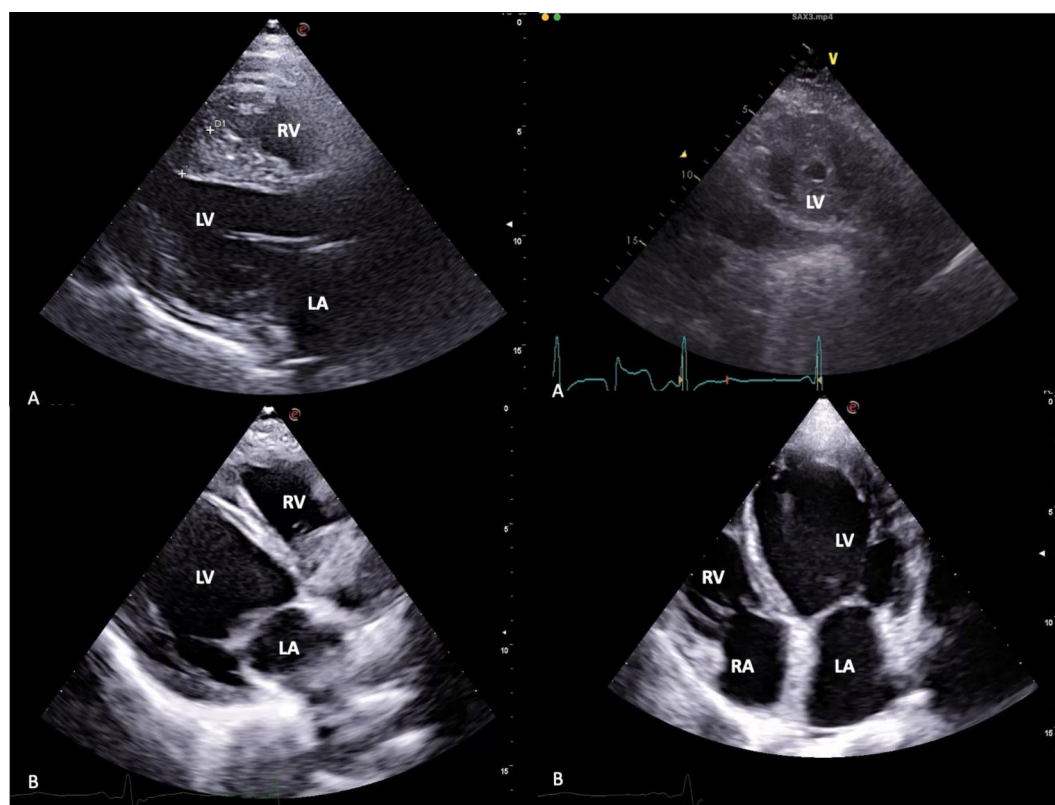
Echocardiographic features in two patients with *TRIM63*-related HCM at different disease stages. Top panel: Echocardiographic images from a recently diagnosed patient with *TRIM63*-related HCM. Parasternal long-axis (left) and short-axis (right) views show concentric left ventricular hypertrophy, with marked thickening of the interventricular septum and apical segments. Left atrial enlargement is also noted. Bottom panel: Echocardiographic images from a patient with *TRIM63*-related HCM in the end-stage phase. There is left ventricular dilatation and global hypokinesia with biventricular involvement, consistent with a hypokinetic-dilated evolution. Four-chamber and parasternal views demonstrate dilatation of the left and right atria. Abbreviations: LV: left ventricle; RV: right ventricle; LA: left atrium; RA: right atrium; HCM: hypertrophic cardiomyopathy.
